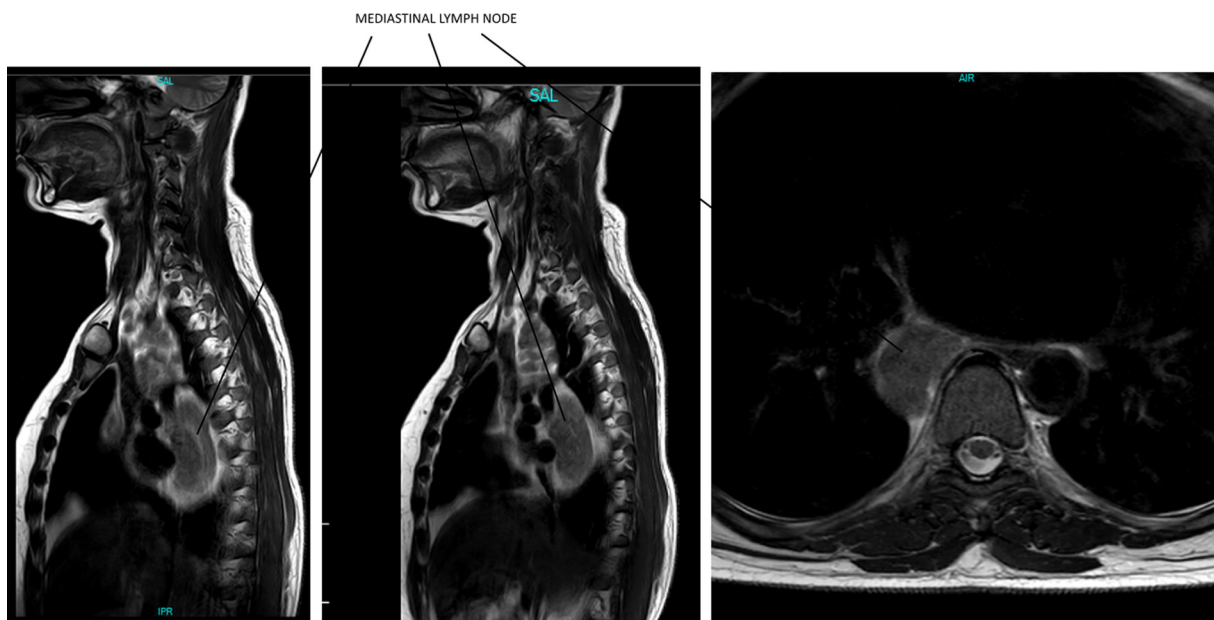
Thoracic magnetic resonance imaging showing a large mass of lymph nodes occupying the superior and posterior mediastinum.
